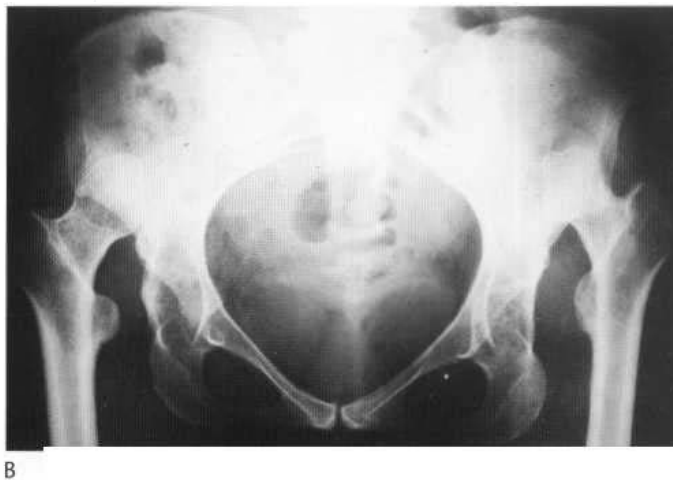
(A) Bilateral congenital dislocation of the hip. The initial radiograph demonstrates lateral subluxation of both femoral heads with dysplastic acetabula. The ossifying nucleus can be seen developing at the midpoint of the growth plate. Its eventual position could be predicted from the original plain film. (B) End-stage undiagnosed bilateral CDH. The femoral heads have molded in their new situation and articulate with the iliac blades.
